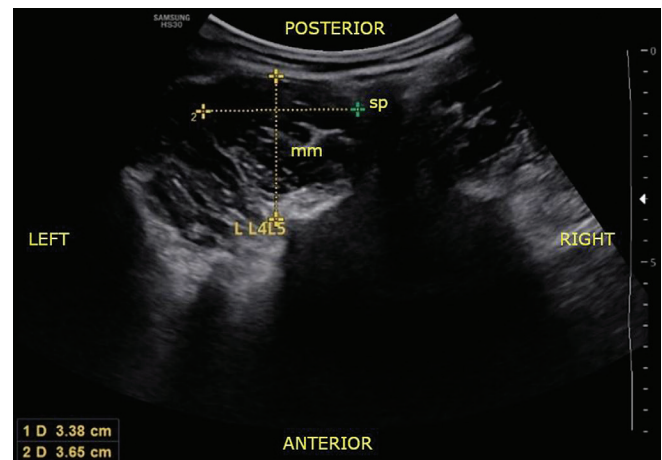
Cross-sectional ultrasound images of the L4-L5 lumbar multifidi with AP-L measurements.
